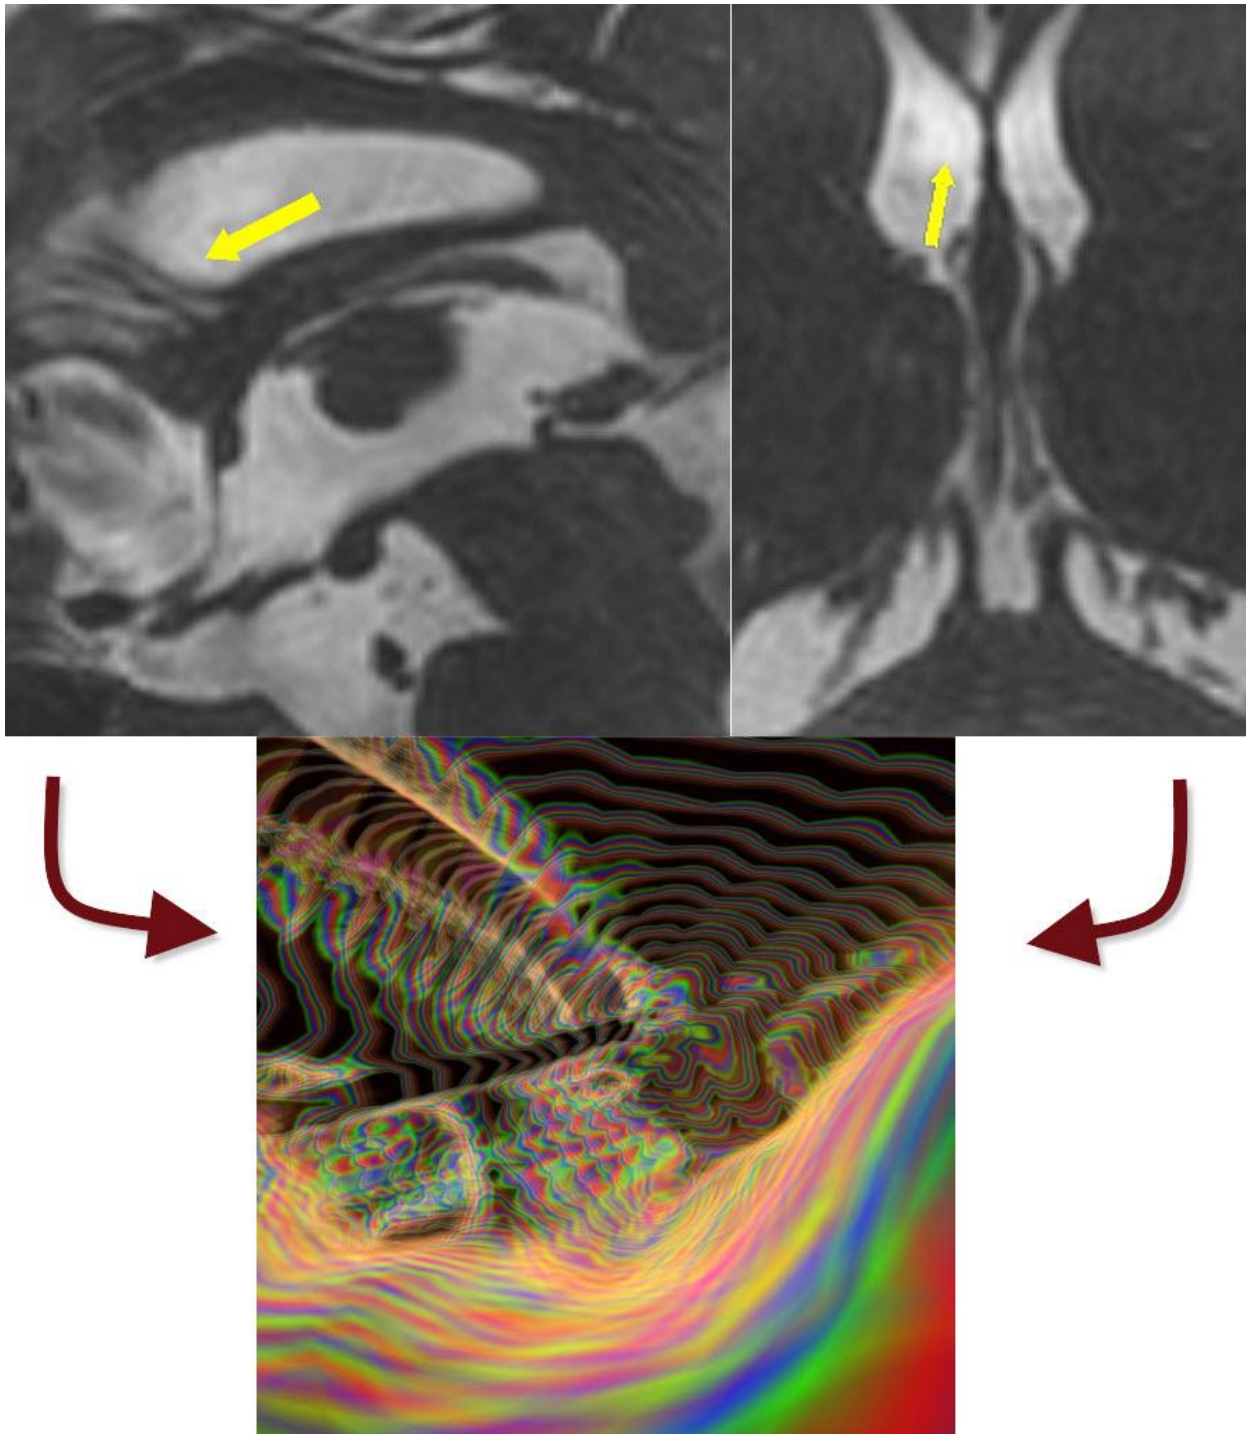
Original sagittal and axial MR image employing 3D constructive interference in steady state (3D CISS) pulse sequence (top) showing the view point by the arrow.
